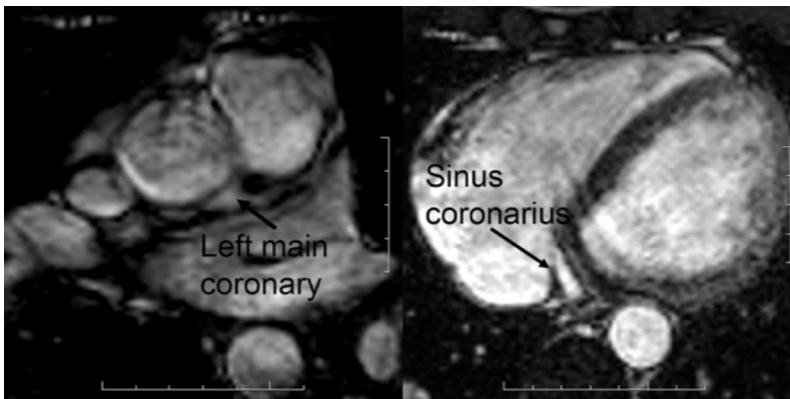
Axial slices of the cardiac MR images (Study III). On left: Orifice of the left main coronary. On right: drainage of the sinus coronarius.
